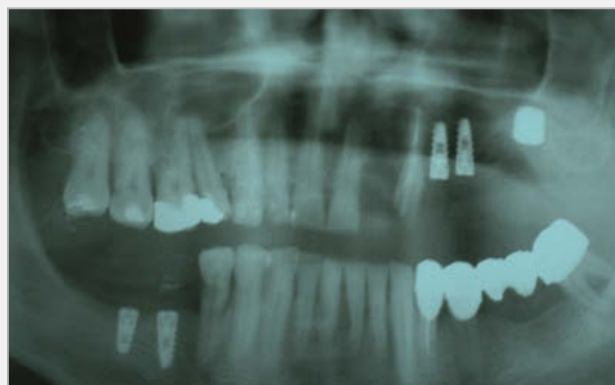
Case 2 - Postoperative x-ray with the 6mm length and 6mm diameter Bio-com implant. The patient refused the classic external sinus elevation procedure.
